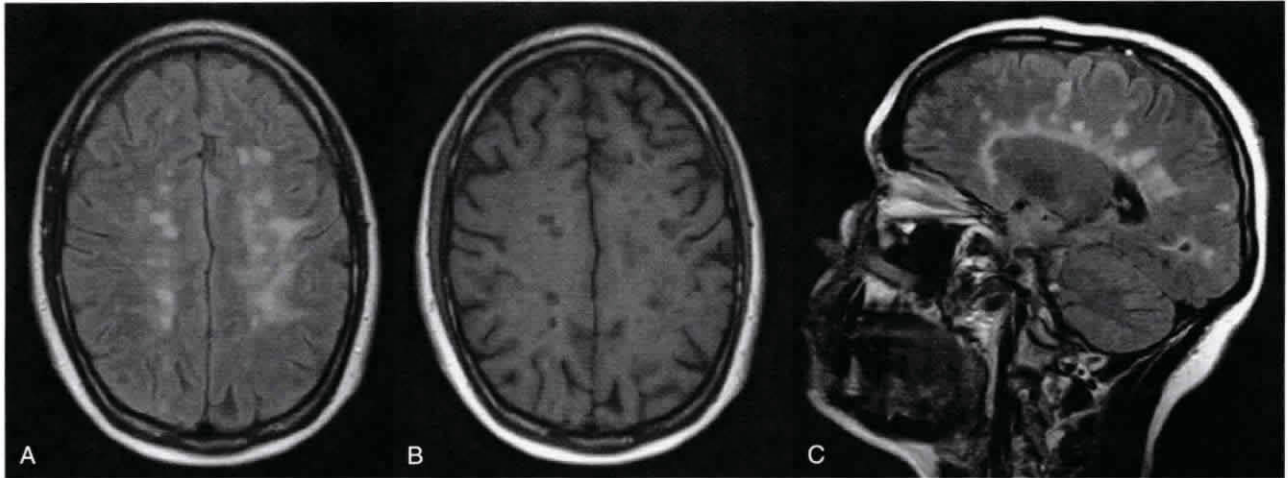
• Brain MRI of a patient with MS. A, Axial fluid-attenuated inversion recovery (FLAIR) image showing multiple hyperintensities. B, Axial T1-weighted image at the same level. Some of the areas of FLAIR hyperintensity are also hypointense on T1-weighted images. C, Sagittal FLAIR image showing periventricular hyperintensities.
